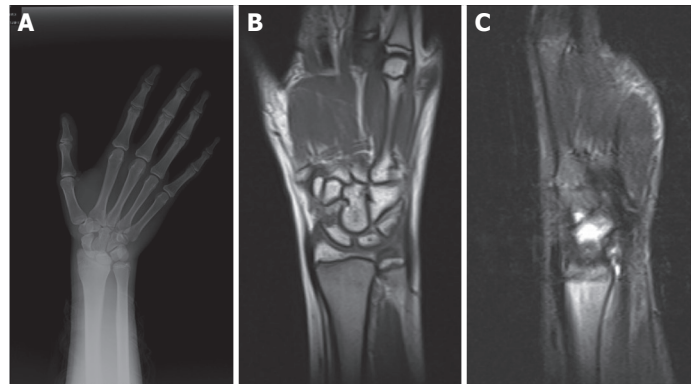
A 14-year-old male patient was admitted to the emergency department after falling on his right wrist. (A) AP X-ray in the ulnar deviation at the time of admission. (B, C) Wrist MRI taken on day 6, fracture line in the scaphoid distal in coronal and sagittal section.
